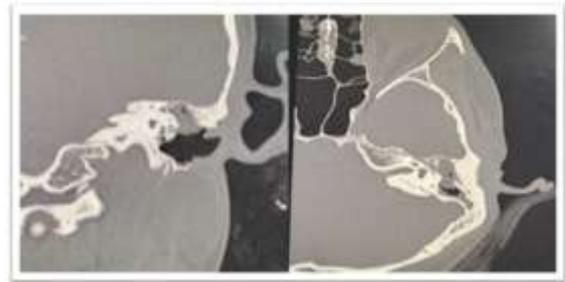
CT images of left temporal bone shows soft tissue density in the left middle ear cavity extending via aditus ad antrum into the mastoid cavity with erosion of scutum. Note the non-visualisation of left stapes and handle of malleus. There is also dehiscence of lateral wall of horizontal part of facial canal and lateral semicircular canal
